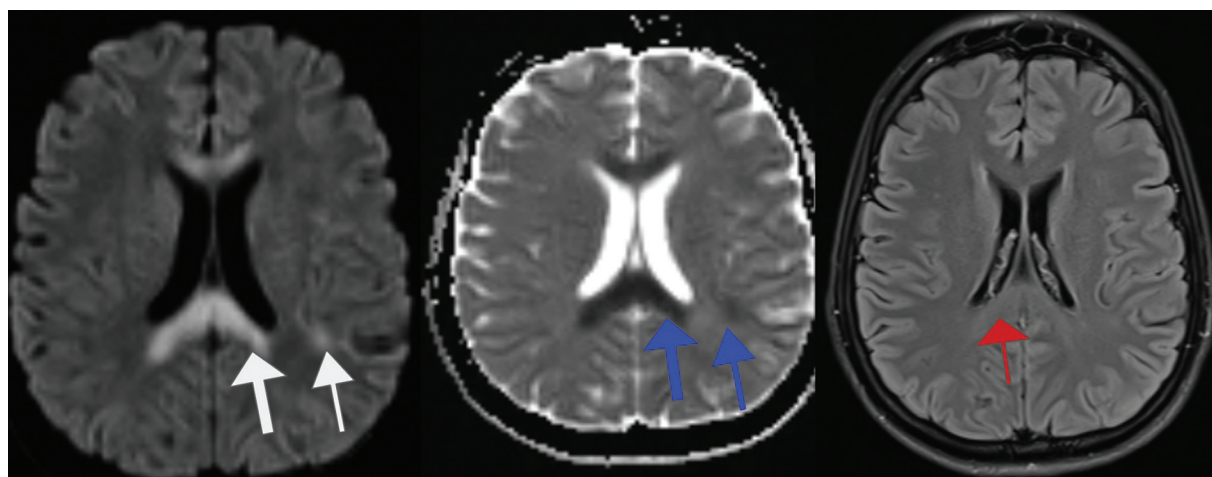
Diffusion-weighted (DW) sequence showing inverted hyperintensities in the corpus callosum and bilateral subcortical regions (white arrow) with corresponding hypointensities on apparent diffusion coefficient sequences (blue arrows) and subtle hyperintensity in the corpus callosum on T2-weighted (T2W) sequence (red arrow).
